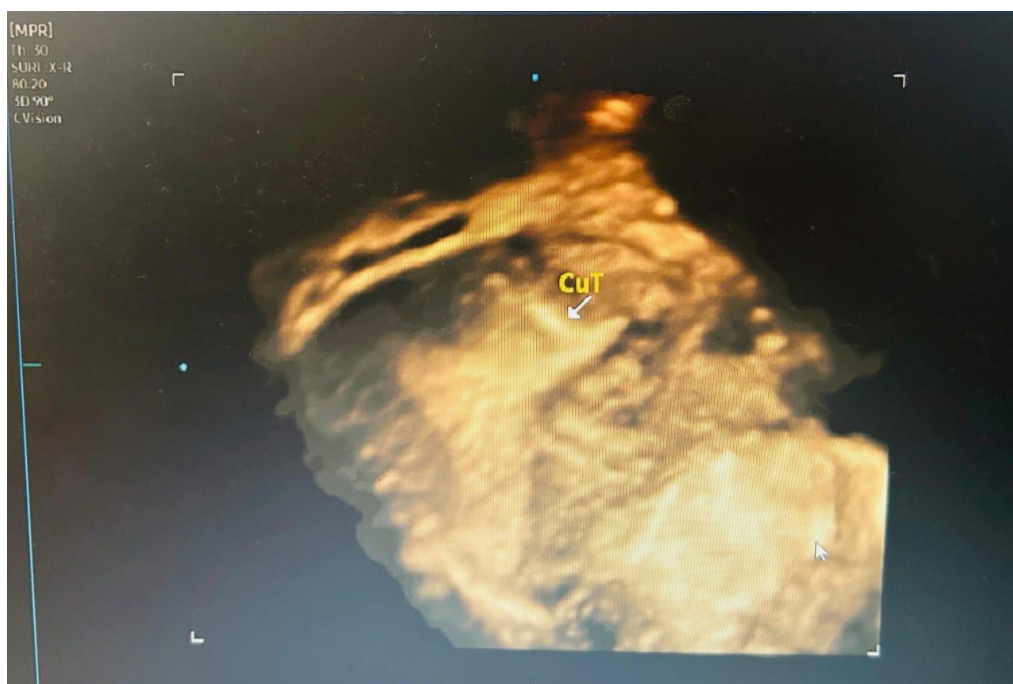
Ultrasound showing fractured Copper IUD.
